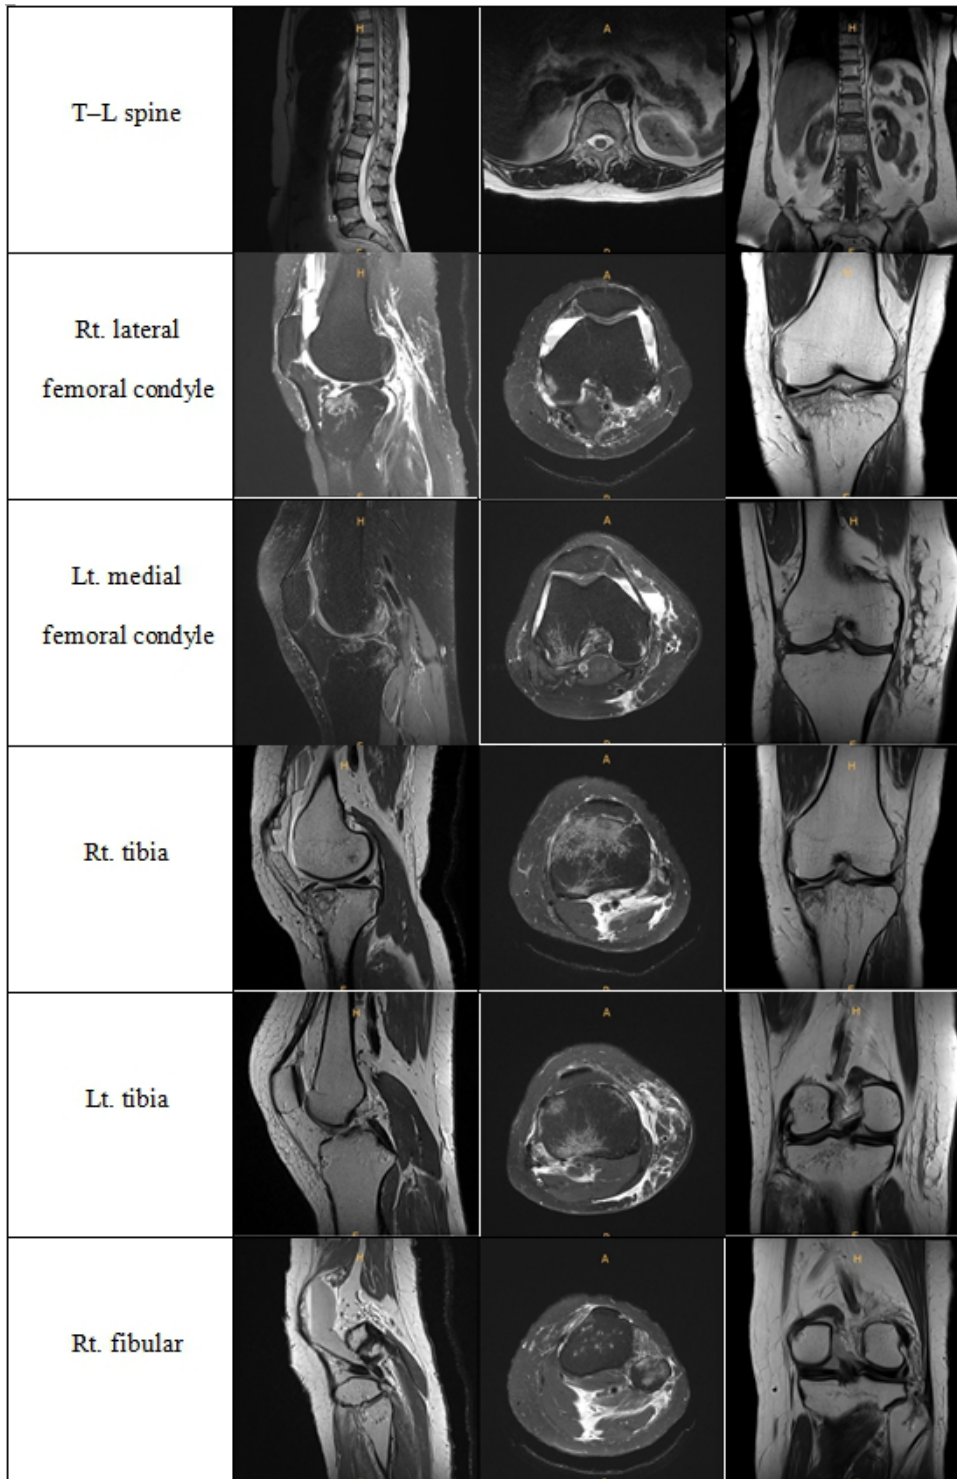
Magnetic resonance imaging of the T-L spine and bilateral knee on onset. Rt., right; Lt., left.
